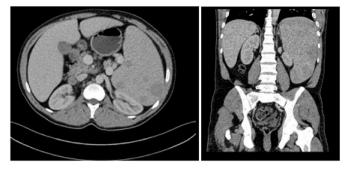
CT images show multiple splenic lesions.
